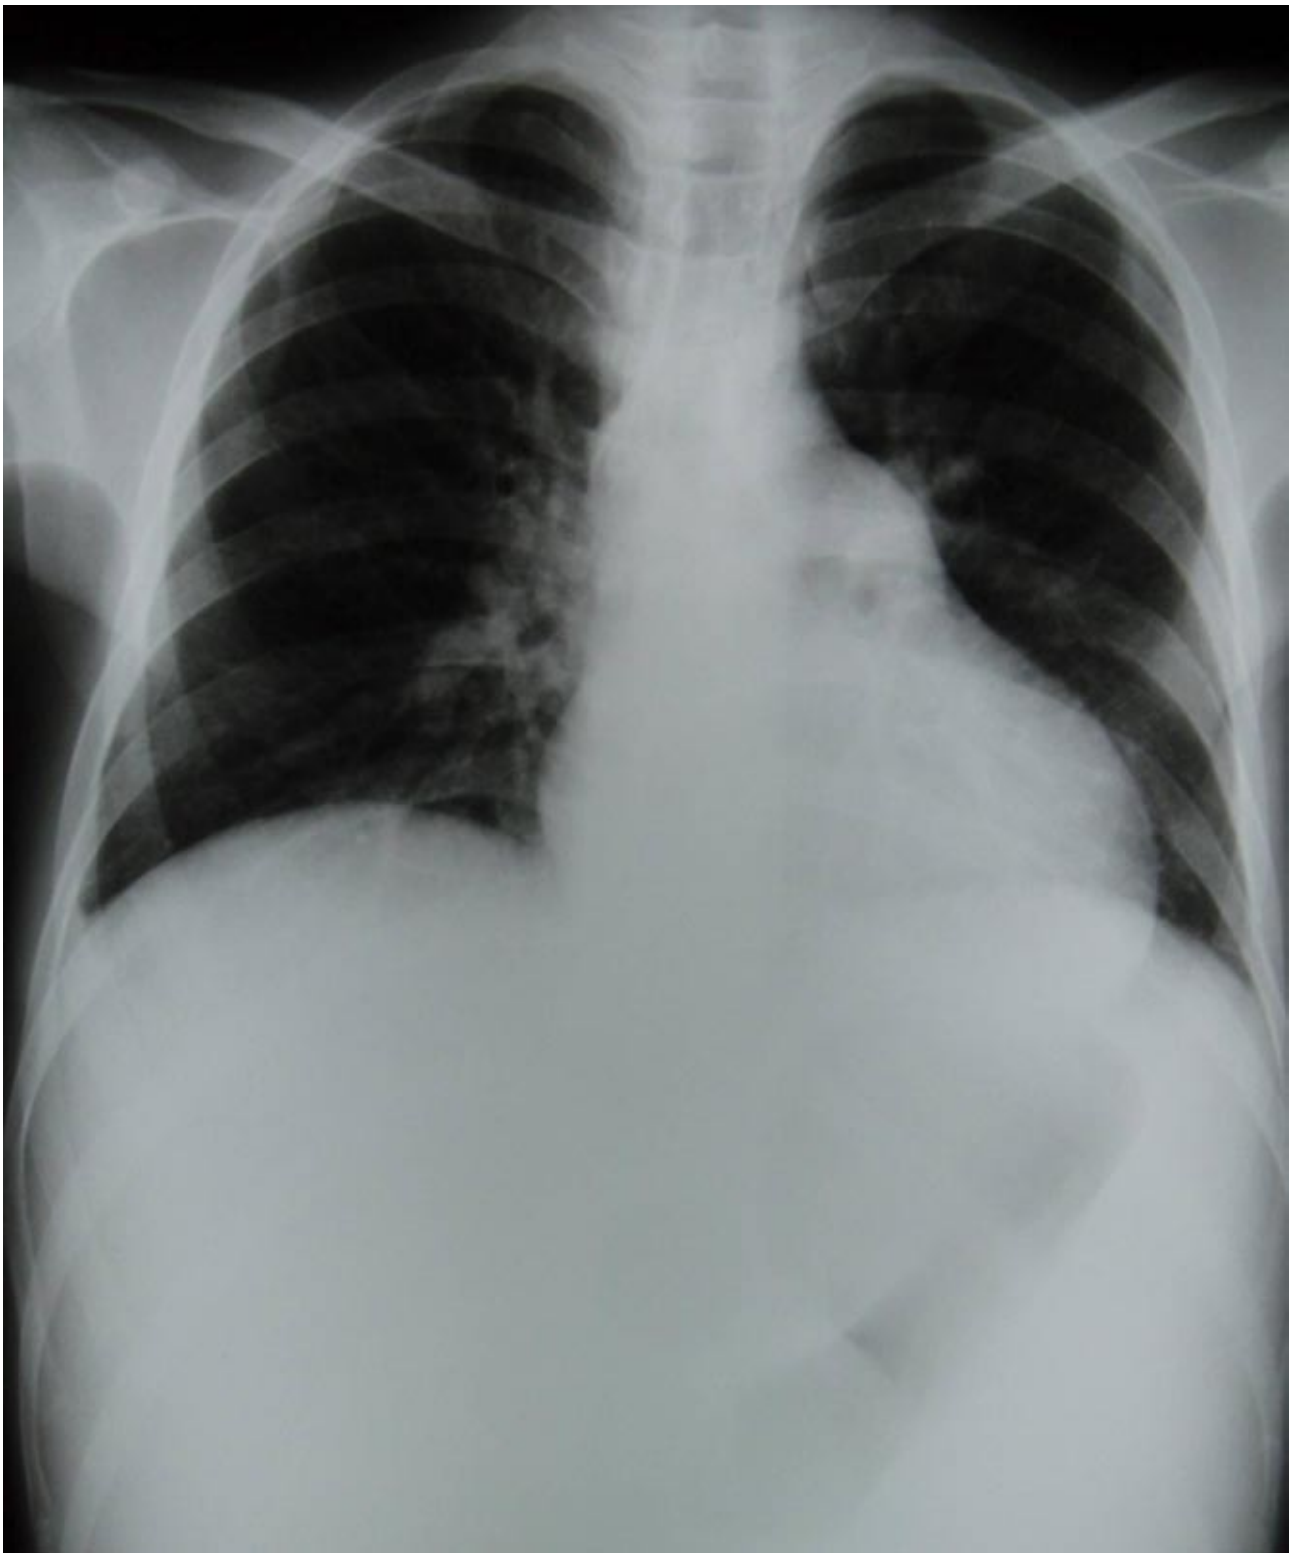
Patient's chest X-ray during the second hospitalization in our Department (16.06.2007)
